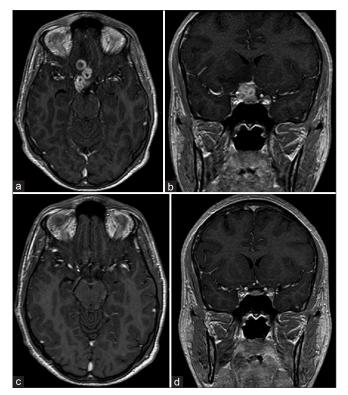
Brain magnetic resonance imaging shows a sellarsuprasellar lesion, (a and b) heterogeneous enhancement with gadolinium is observed on the T1 sequence. (c and d) The lesions exhibit complete resolution following treatment.
